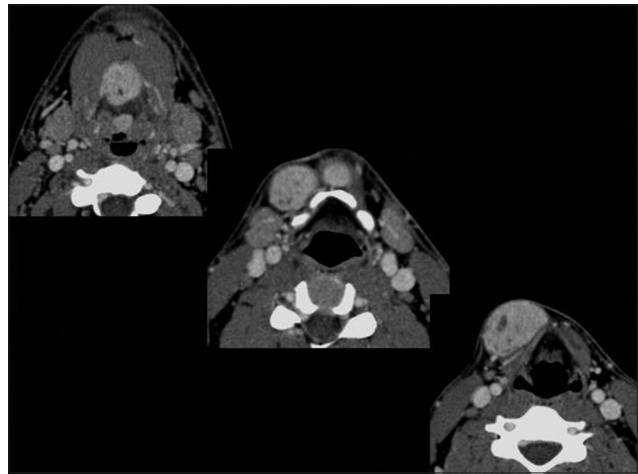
Axial contrast enhanced computed tomography scan at same levels as above demonstrating uniform almost homogeneous brilliant enhancement
